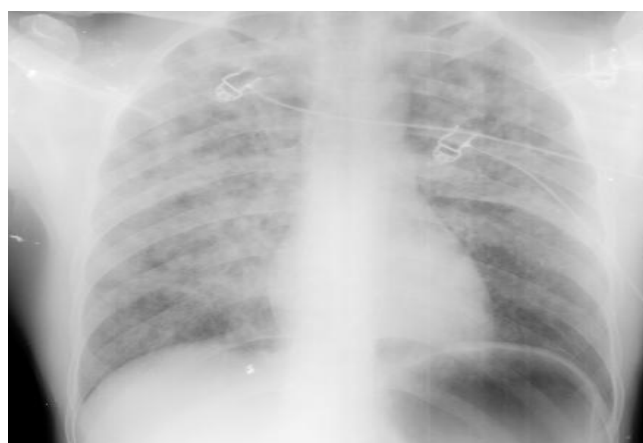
Postoperative chest radiograph showing infiltrative areas consistent with bilateral pulmonary edema
